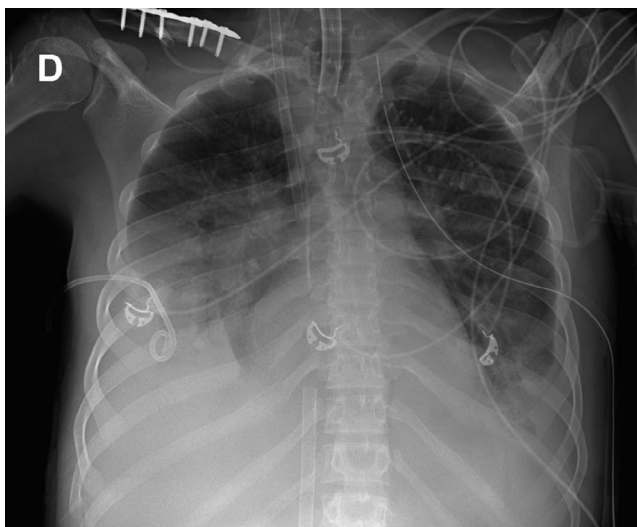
Chest X-ray for patient 2. It shows the jugular ECMO cannula and the femoral ECMO cannula
